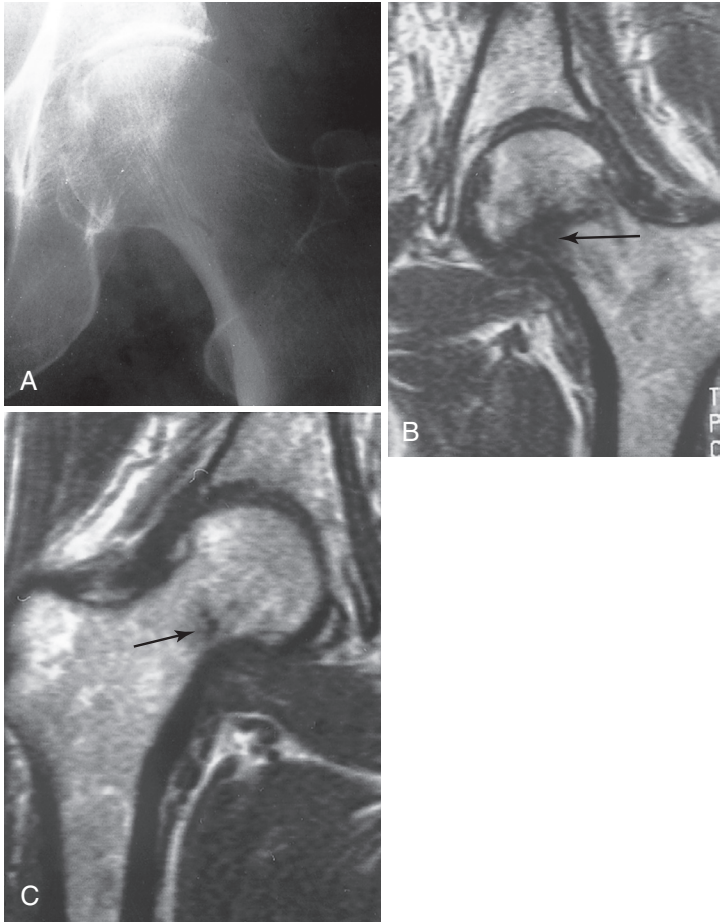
Imaging of occult hip fracture. A, Anteroposterior radiograph of the left hip demonstrates no evidence of fracture. B, Coronal T1-weighted magnetic resonance imaging (MRI) clearly shows a well-demarcated line of decreased signal in the subcapital region of the left femoral neck consistent with a nondisplaced fracture (arrow). C, MRI of the right hip shows a subtle medial femoral neck fracture (arrow) not demonstrated on the conventional radiograph. (From Adam A, et al. Grainger & Allison's diagnostic radiology. 5th ed. Edinburgh: Churchill Livingstone, 2008, Fig. 46-73.)
